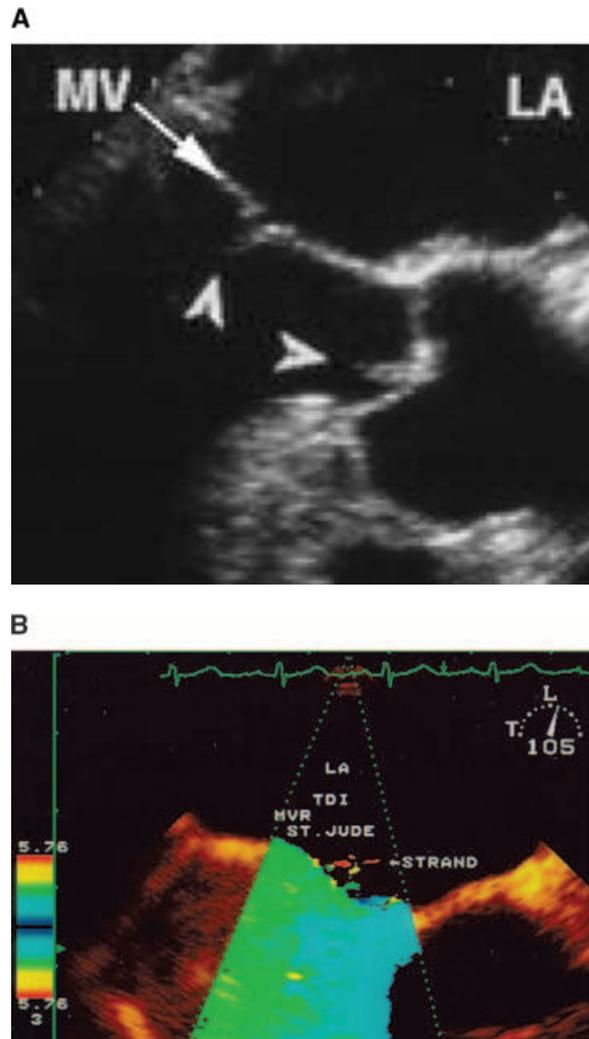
A. TEE in the mid-esophagus (157°) of a patient with an aortic valve Lambli's excrescence (horizontal marker). B. Systolic TEE frame (105°) in the mid-esophagus of a patient with a St. Jude mechanical mitral prosthesis. Using tissue Doppler imaging (TDI), a mobile valve strand is noted (arrow—red color strand) in the left atrium (LA). (Fig. 4A modified with permission from Ref. 5).
